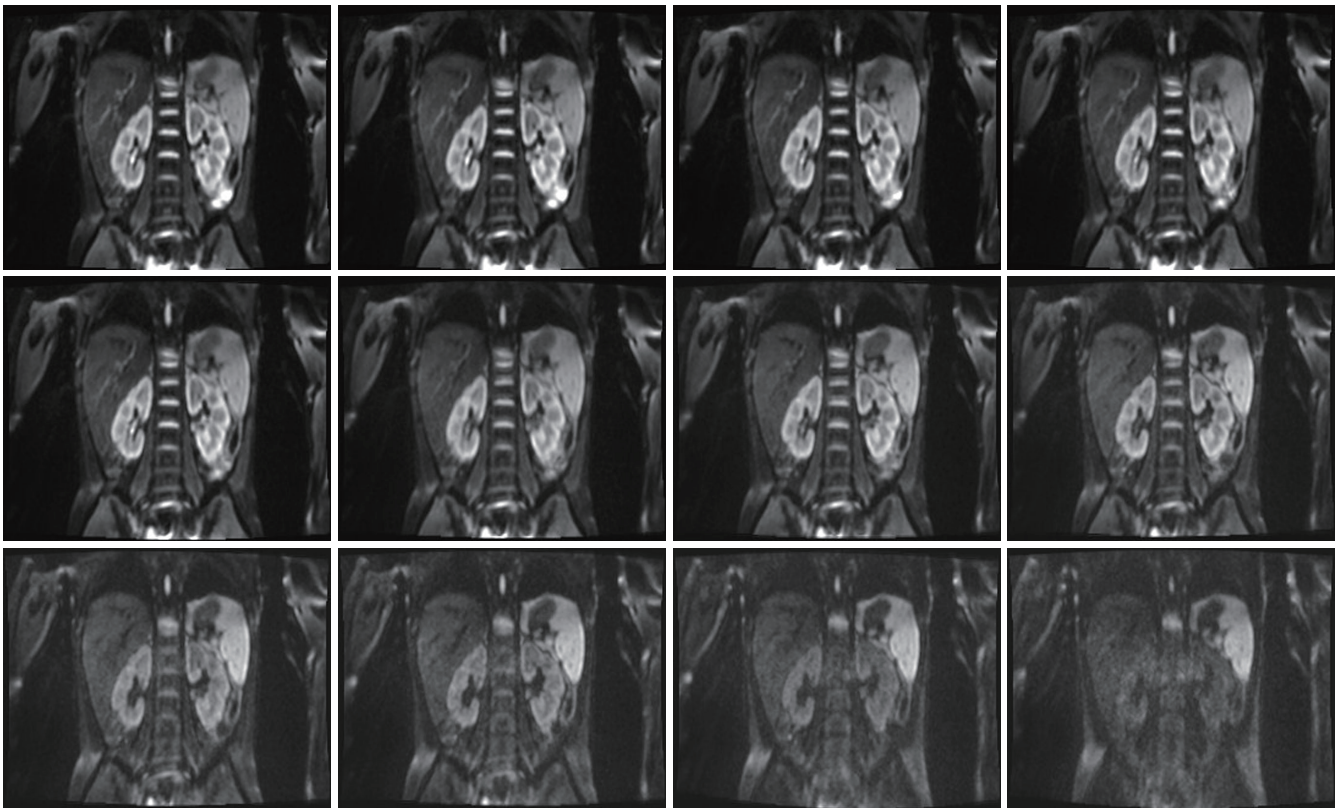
DWI images of normal bilateral kidneys with different b values in 3-year-old children. The images with multi-b values (10, 20, 30, 50, 100, 200, 300, 500, 800, 1,000, 1,500, 2,000 s/mm^2) are shown from left to right and from top to bottom. When the b value was less than 1,000 s/mm^2 , the renal cortex and medulla were clearly demarcated, and the cortex signal was higher than that of the medulla. At higher b values, the kidney contour was clear, indicating that the multi-b values DWI image quality for young children may be superior. DWI, diffusion weighted imaging.
